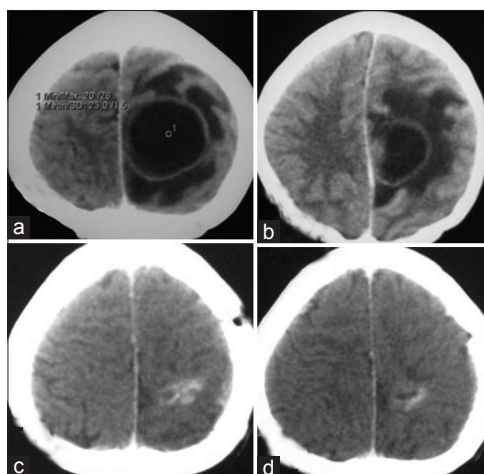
(a and b) Contrast CT scan of brain axial section showing left sided parasagittal fronto-parietal abscess; (c and d) contrast CT scan of brain after completion of treatment resolution of abscess with some residual calcification. CT: computed tomography
